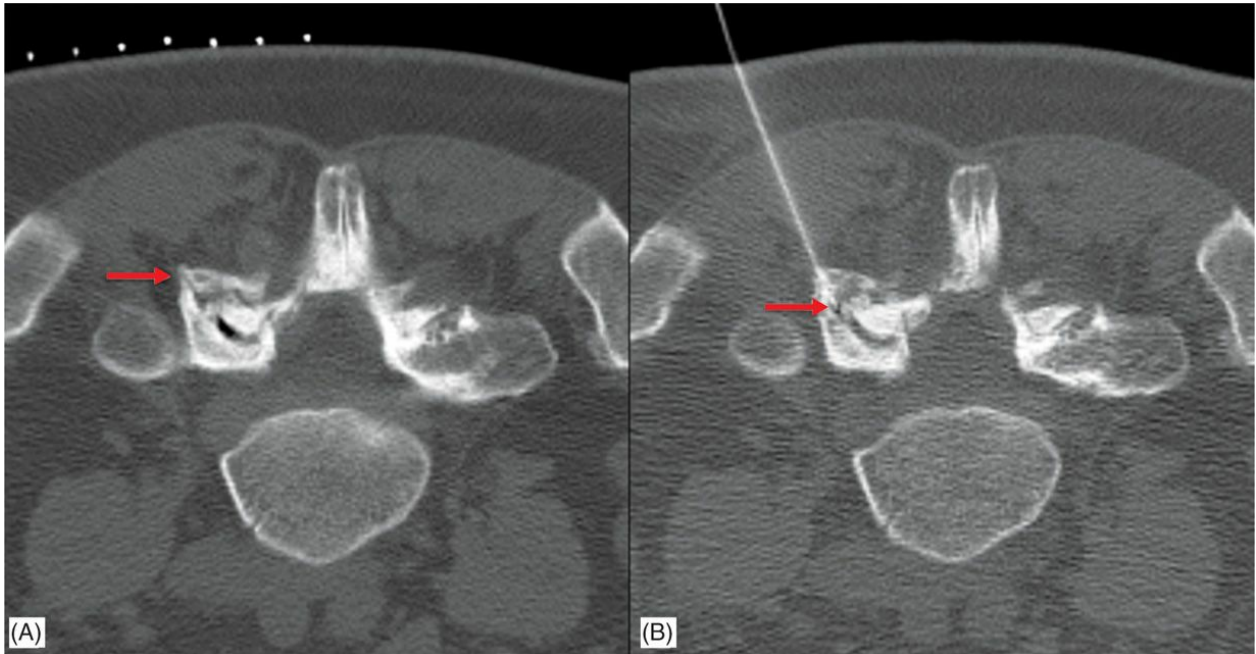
CT-guided facet joint injection. (A) Axial prone CT clearly identifies large facet joint osteophytes (arrow) that would make intra-articular needle position difficult to achieve under fluoroscopic guidance. (B) CT guidance facilitates accurate targeting of the narrowed articular space, and intra-articular position (arrow) is achieved.
